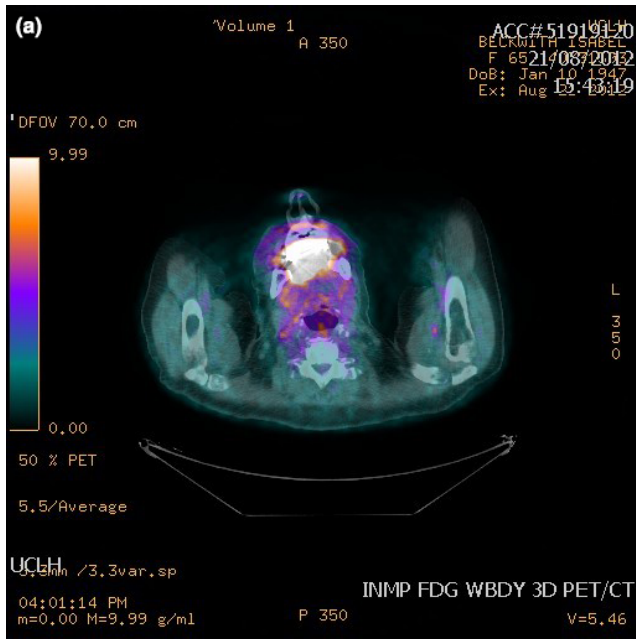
(a) and (b). PET-CT showing extensive uptake in the floor of mouth and bilateral cervical nodes (R>>L) from a large T4 SCC of the anterior floor of mouth.
